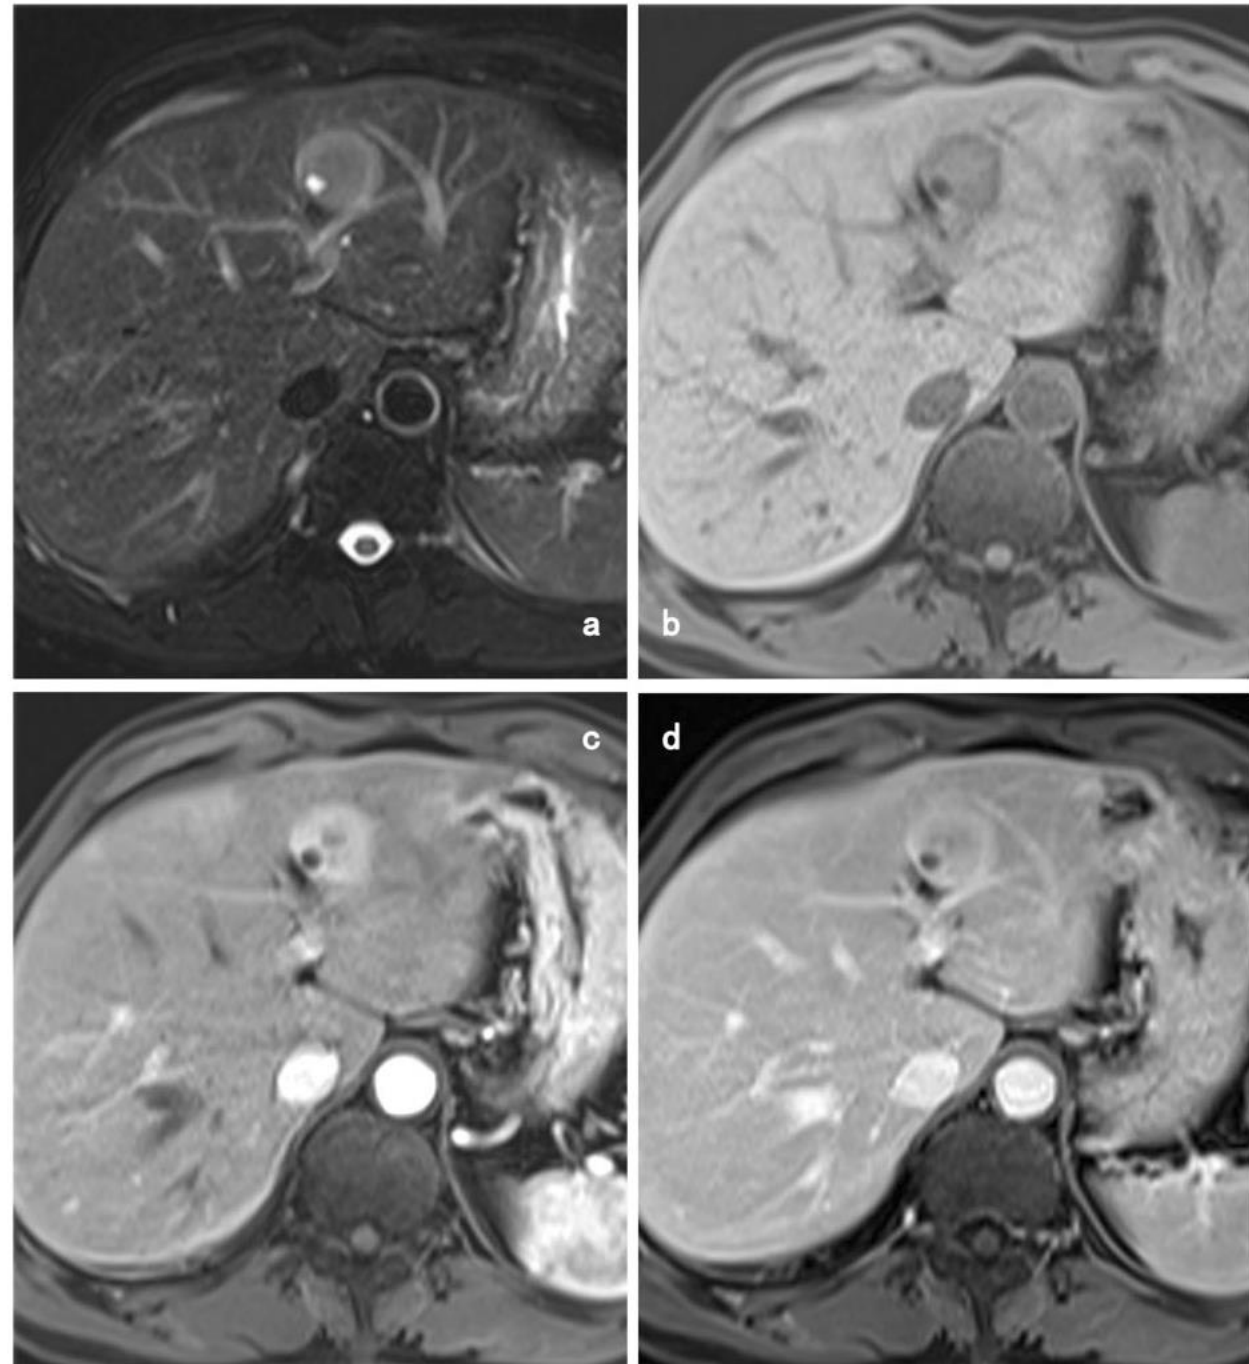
MR images in a 56-yearold man with LEICC. Axial a T2-weighted, b pre-contrast T1-weighted, c arterial phase, and d portal phase gadoliniumenhanced MRI scans. The bicentric tumor (longestdiameter, 59 mm) with a smooth margin exhibits slightly hyperintensity on T2-weighted image (a), hypointensity on precontrast T1-weighted image (b), non-rim hyperenhancement on arterial phase (c), and washout on portal phase (d). There is no perilesional enhancement or liver capsular retraction. Biliary dilatation can be observed within the tumor. LEICC lymphoepithelioma-like intrahepatic cholangiocarcinoma
